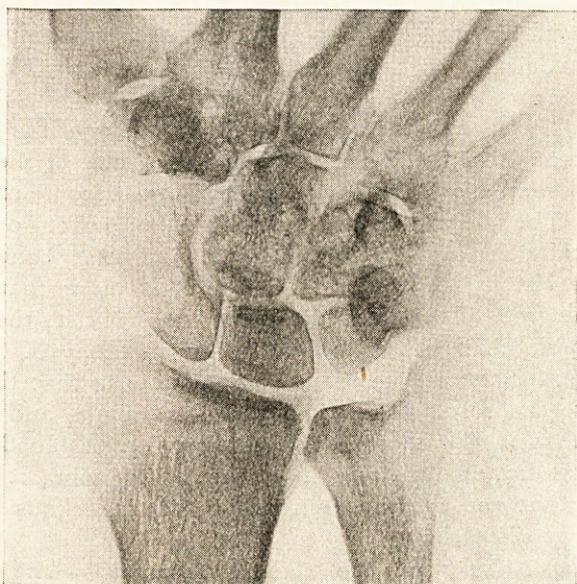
Case I. X-ray a month later: Stippled decalcification now present, with general loss of density.
